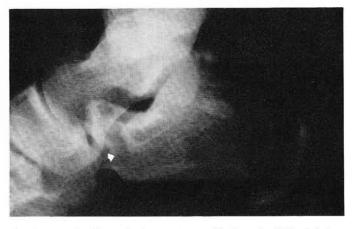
Lateral radiograph demonstrates effusion of subtalar joint.
